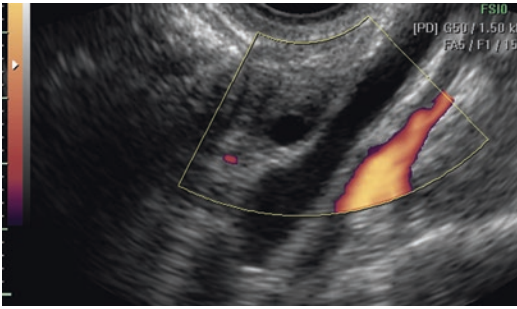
Transvaginal scan of left pelvic sidewall showing a dilated ureter as a straight tubular structure with anechoic content. The ureter is delimited by a thick muscular wall, and this helps in differentiating with an iliac vessel. It is generally possible to visualize the peristalsis in the ureter by waiting for a few seconds. Moreover, Doppler helps in the differential diagnosis as the dilated ureter shows no blood flow inside
